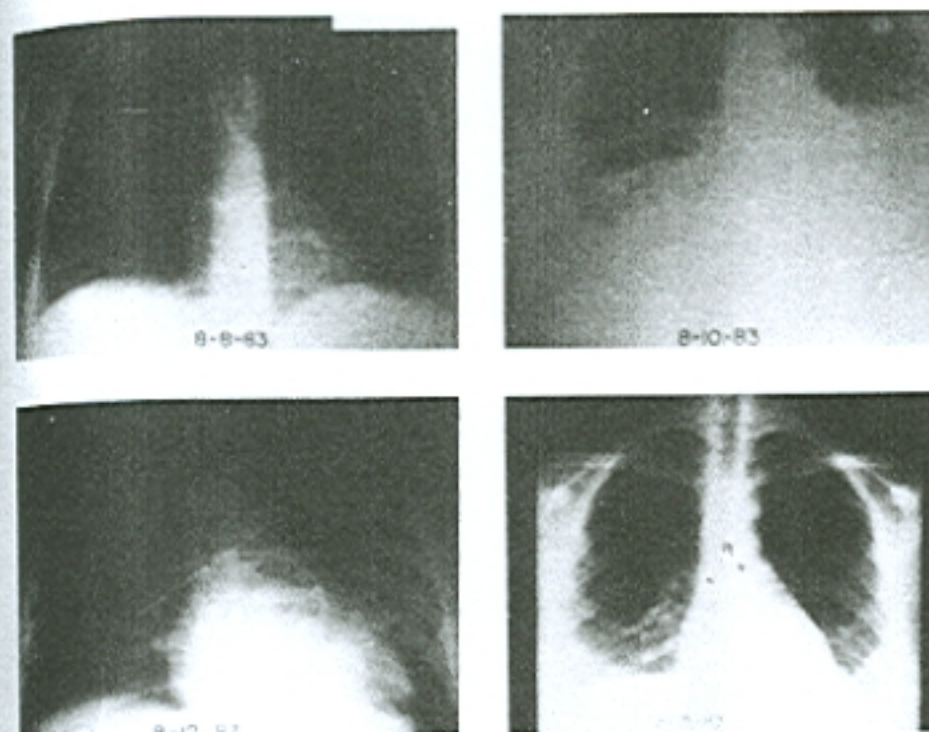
An 18-year-old multipara with acute pyelonephritis at 20 weeks had a normal radiograph when admitted 8-8-83. Respiratory distress 20 hours later was accompanied by a left-sided pulmonary infiltrate, which progressed to bilateral infiltrates by 8-10-83. The infiltrates improved, and she had a normal x-ray by 8-15-83. (From Cunningham and colleagues, 1987, with permission.)
